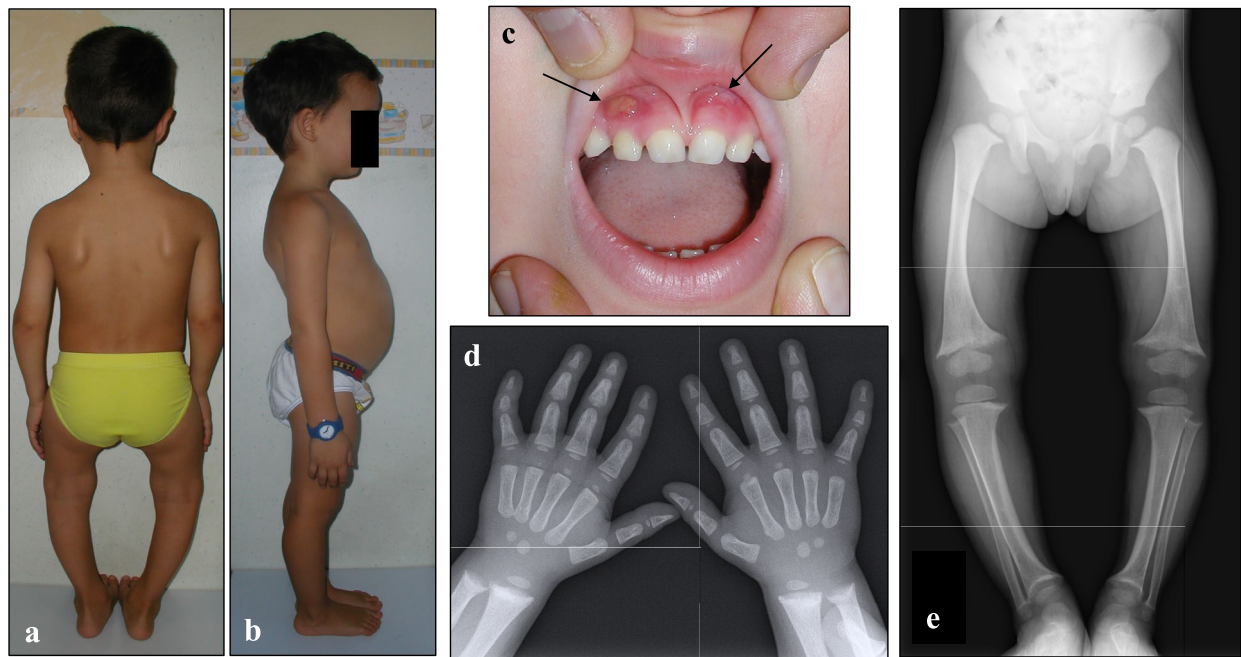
Typical phenotype and radiological lesions in children with XLH. a Severe short stature (-4.6 Z-score) with body disproportion and genu-varum in a 6.5-year-old male. b Severe short stature (-3.0 Z-score) with body disproportion, exaggerated lordotic posture to compensate for the anterior bowing of the lower limbs, and craniostylosis in a 6-year-old male. c Spontaneous gingival fistulae (black arrows) corresponding to deciduous left and right maxillary lateral incisors in a 4.3-year-old male. d X-ray features of the wrist in a 1.8-year-old female: widening and fraying of the epiphyseal plate and metaphyseal concavity of the ulna. e X-ray features of the lower limbs in a 2.1-year-old female: genu-varum and distal medial femoral and tibial bowing with widening and fraying of the distal epiphyseal plate of the femur and tibia and of the proximal epiphyseal plate of fibula and medial epiphyseal plate of the tibia
